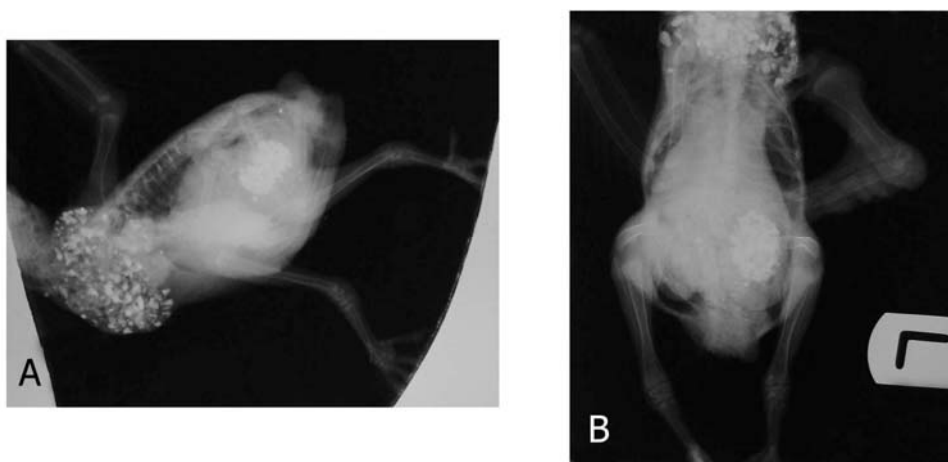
Lateral (A) and Ventrodorsal (B) whole body radiographs of the bird described in figure 1.
